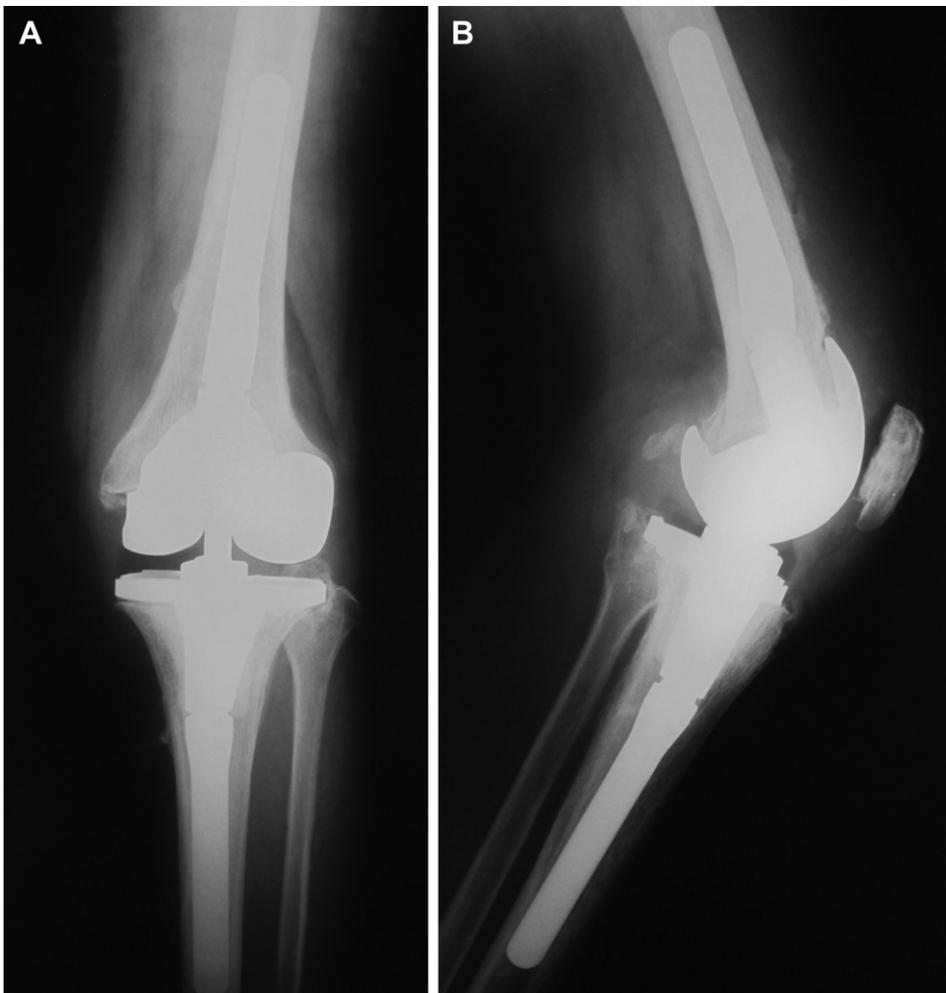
X-rays after reimplantation surgery.
